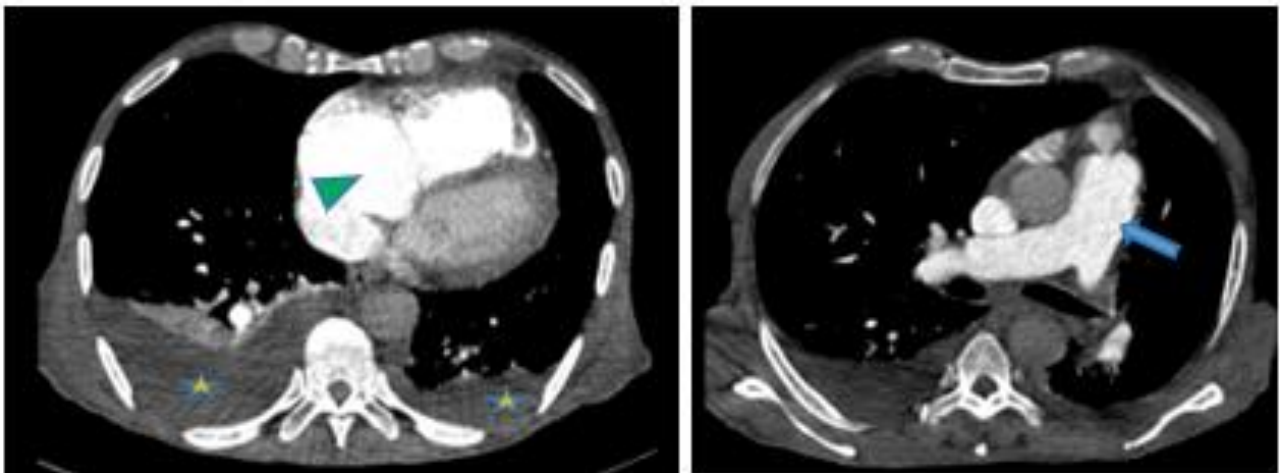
CT pulmonary angiography Mediastinal window with intravenous contrast showing dilatation of the main pulmonary artery (arrow), enlargement of the right cardiac chambers (arrowhead) and bilateral pleural effusions (asterisk)
